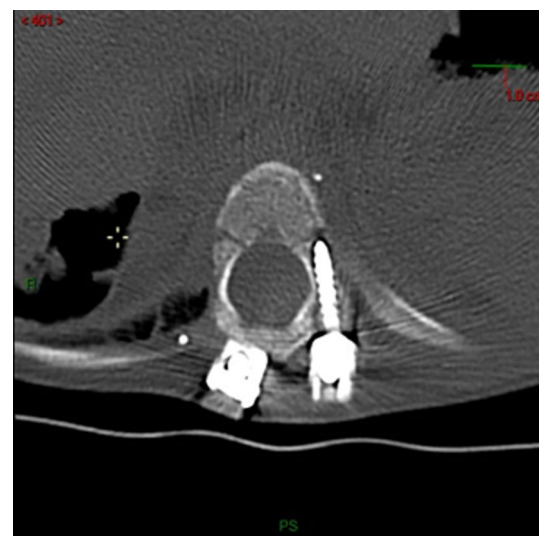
Postoperative axial CT reconstruction showing the very small T10 left pedicular screw at 15 weeks. Note that the screw tip does not perforate the growth plate
